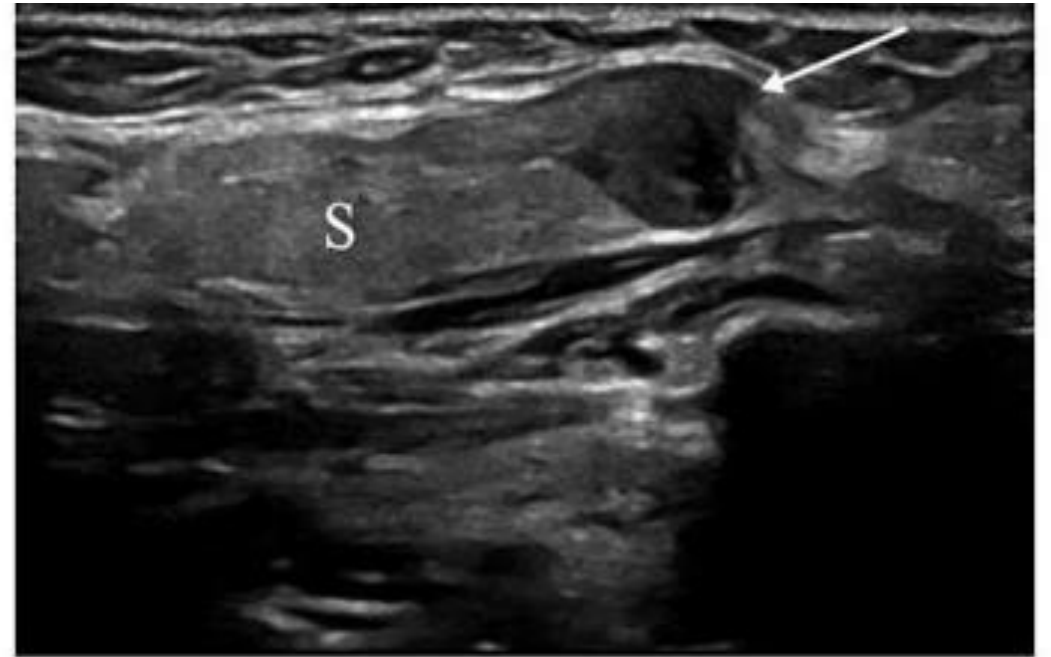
Grey scale sonogram of the right submandibular gland (S). The image demonstrates an ill-defined 8-mm hypoechoic mass medially within the right submandibular gland (white arrow).
